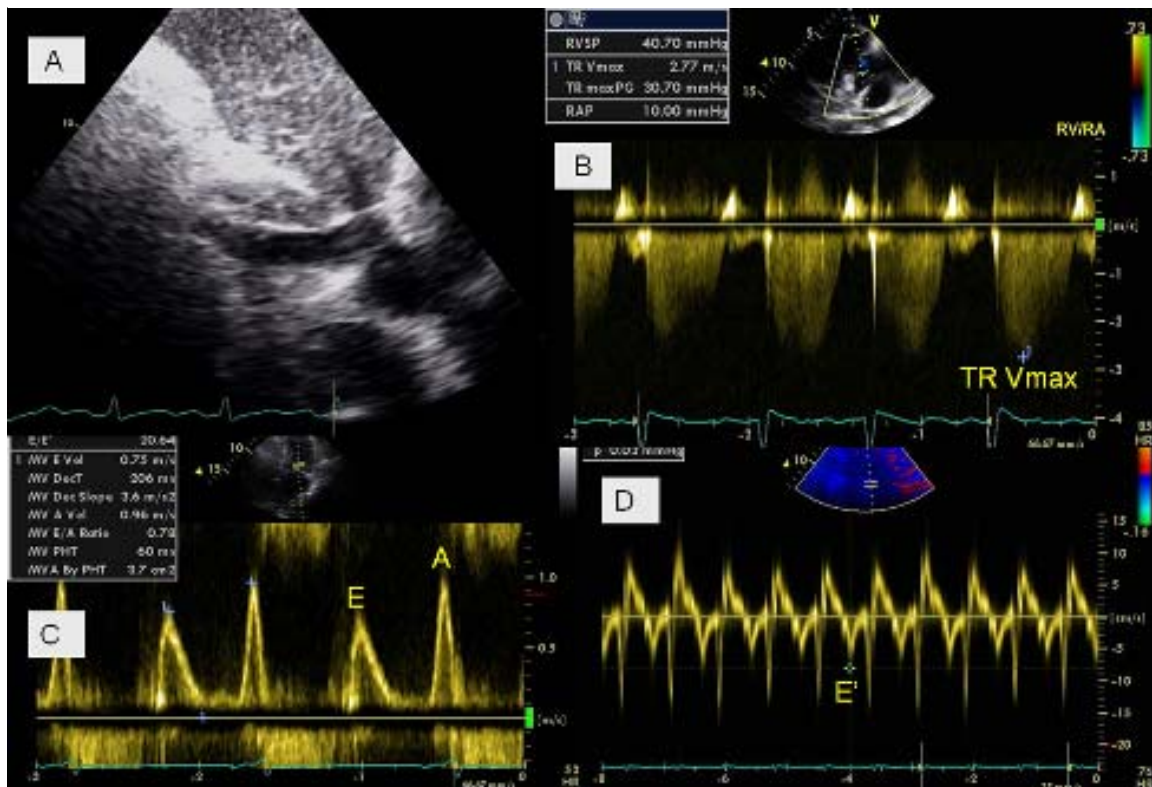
Two-dimensional and Doppler echocardiography is a powerful tool for hemodynamic assessment (see text for details). (A) Inferior vena cava (IVC) diameter. (B) Tricuspid regurgitation jet velocity ($TR V_{max}$), calculated pressure gradient, and estimated right ventricular systolic pressure. (C,D) Ratio of peak early mitral inflow velocity [E] and tissue Doppler velocity of the medial or lateral mitral annulus in the early phase of diastole [E'] provides an estimate of the left ventricular end diastolic pressure.
